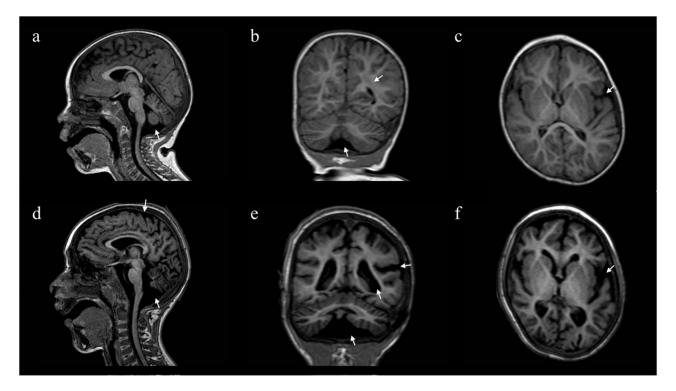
Brain MRI follow-up. Axial, sagittal and coronal T1-weighted sequences of the brain MRI performed at (A-C) 26 months and (D-F) at 6 years of age. Neuroimaging at first evaluation showed (A) ventricular widening with initial signs of cerebellar atrophy, (B) atrophy of the cerebellar vermis relatively sparing cerebellar hemispheres and (C) diffuse cortical atrophy particularly in the temporal lobes bilaterally. Follow-up examination showed (D) enlargement of the cerebrospinal fluid spaces, including sub-tentorial, pontine and bulbar cisternae, (E) global reduction of the bi-hemispheric white matter, enlarged cisterna magna (F) progressive cortical atrophy, particularly in the occipital and posterior temporal lobes bilaterally.
